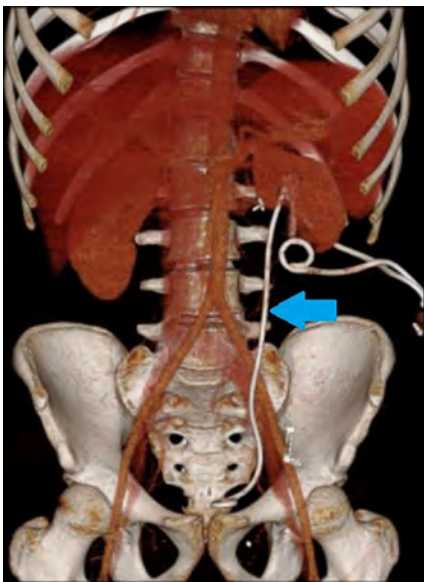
CT 3D rendering of the left double-J ureteral stent (blue arrow), obtained 1 day after placement, with the proximal stent loop in the intrarenal collecting system and the distal loop in the urinary bladder.
